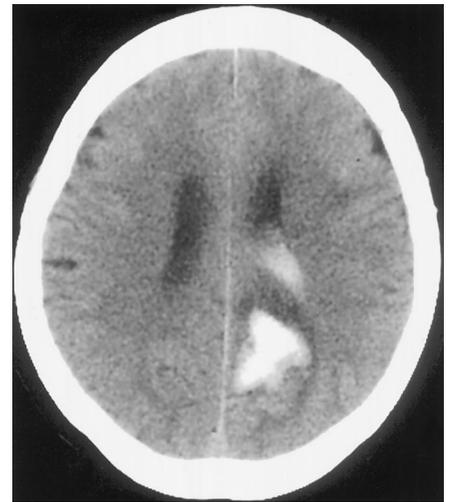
A 67-year-old woman with a history of acute change in mental status and new onset of seizure. Image quality was rated excellent for CT and MR angiography.
